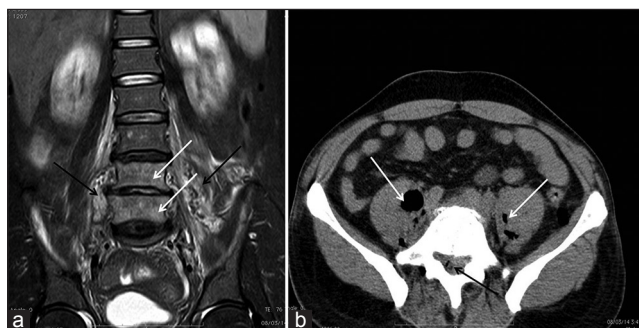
(a) Coronal inversion recovery magnetic resonance images showing abnormal hyperintensity of L4 and L5 vertebral bodies (white arrows) and adjacent bilateral iliopsoas muscles (black arrows). (b) Axial computed tomography image showing presence of airpockets in bilateral psoas muscle (white arrows) and intraspinal location within lower lumbar spinal canal (black arrow)
